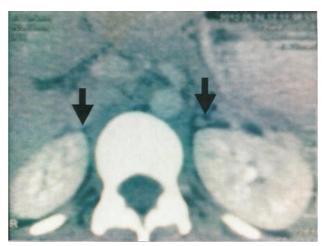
MRI of abdomen showing bilateral atrophic adrenal glands.
